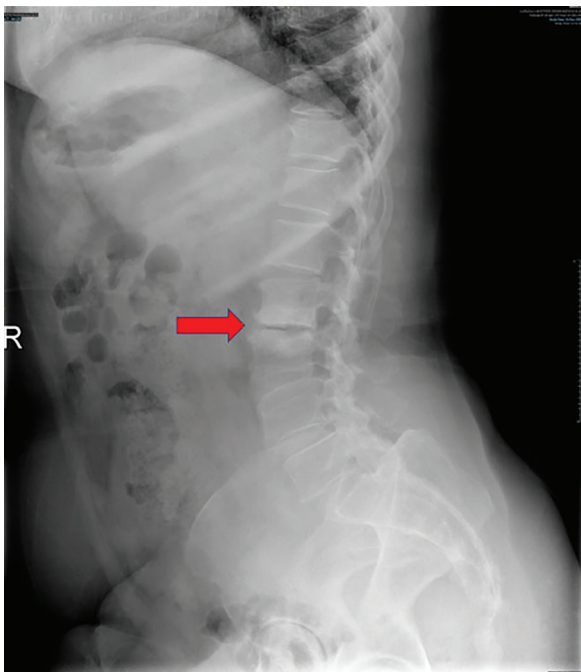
Lateral conventional lumbosacral radiograph. Fifty-six-year-old female patient. Complaints of back pain, night sweats, fever, weight loss. CRP: 0.88 mg/dL. Spondylodiscitis caused by infection. Lumbar MRI: Decrease in L2 and L3 vertebral body heights is evaluated as spondylodiscitis. At the L2-3 disc level, contour irregularities are observed in the palates adjacent to the disc. There is a paravertebral abscess and a right psoas abscess. *Staphylococcus aureus* growth was detected in tissue culture. All 11 of 11 rheumatologists (100%) recognized spondylodiscitis on conventional radiography
